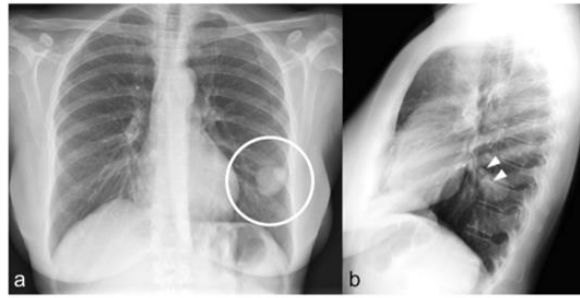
Chest x-ray radiograph shows two well-defined homogeneous masses with a lobed (circle) shape in the left subpleural parenchymal of the lung (a) confirmed on a lateral radiograph (b) which better also shows serpiginous opacities directed from lesion to the hilum, this figure refers to the blood vessels (arrows) .
